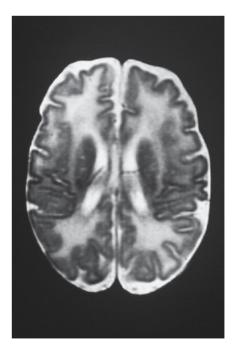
MRI of the head of a 5-week-old infant with Cbl C disease. Abnormal signal was consistent with white matter disease. (Images were kindly supplied by Dr GM Enns of Stanford University.)
